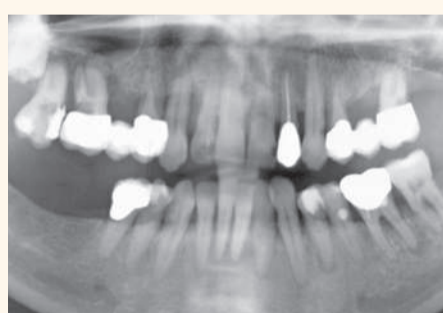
Initial examination. Orthopantomograph.
